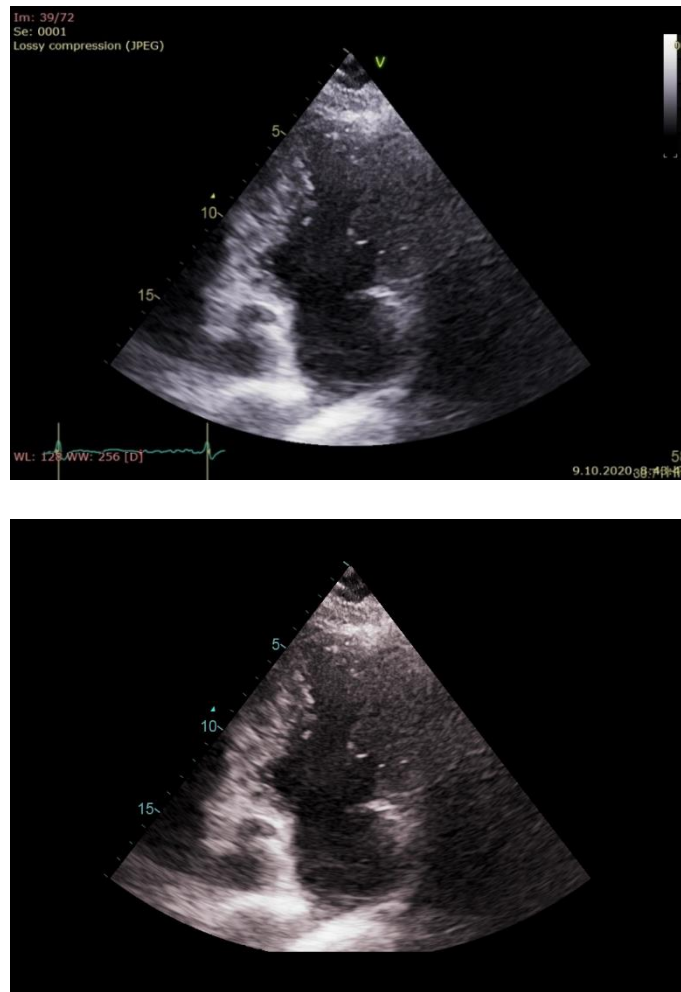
Same ultrasonic image before (up) and after (down) custom masker application
